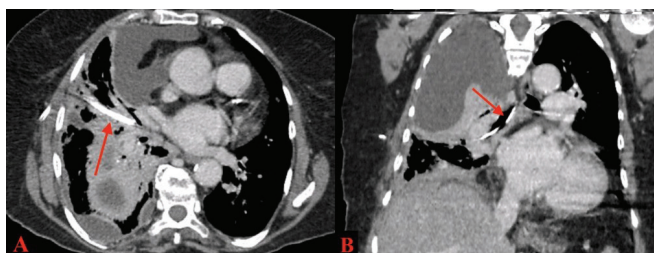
CT of the thorax before the procedure shows the catheter opacity advancing in the middle lobe lateral segment bronchus on the axial axis (a), and its location in the right main bronchus in the coronal axis (b).
